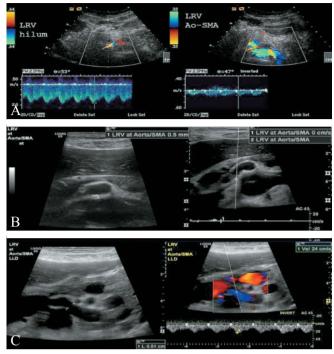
A) Duplex ultrasound images showing the Peak systolic velocity at the hilar segment of the left renal vein (left) and in the aortomesenteric angle (right); PSV ratio 11.3; B) Duplex ultrasound images in supine position in a patient with suspected NCS showing significant compression of the LRV on B mode image (left) and no flow through the vein on color flow (right); C) Imaging in the same patient in left lateral decubitus (LLD) position showing a 10-fold increase in the diameter of the LRV (left) and normal flow and peak systolic velocity (right).
